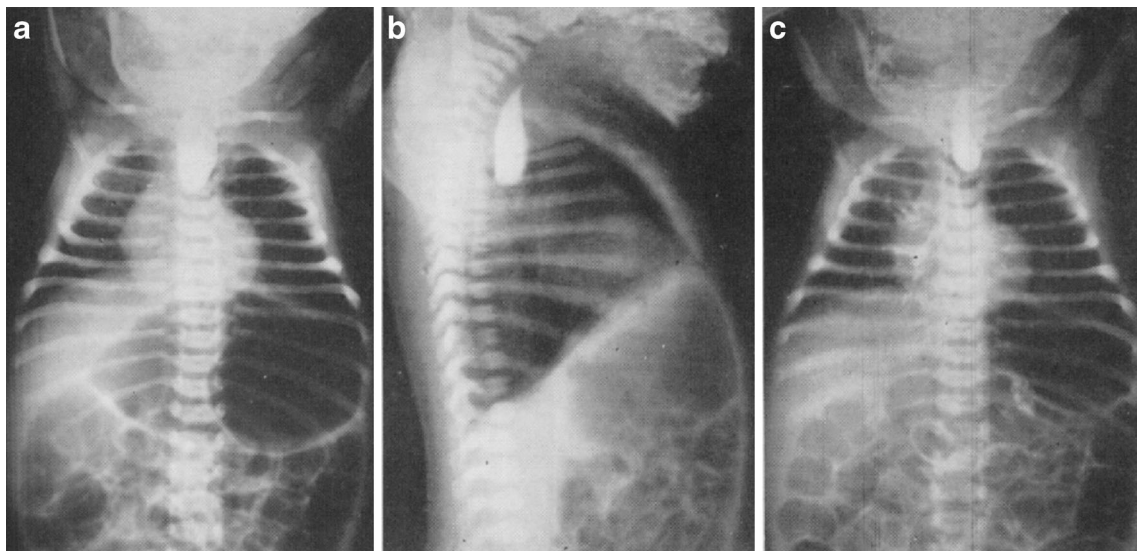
Initial radiographs with upper pouch contrast study (Vogt type 3b) of Haight’s patient [12]. In the initial posteroanterior and lateral views (a and b, respectively), the upper pouch contains contrast and the stomach is markedly
